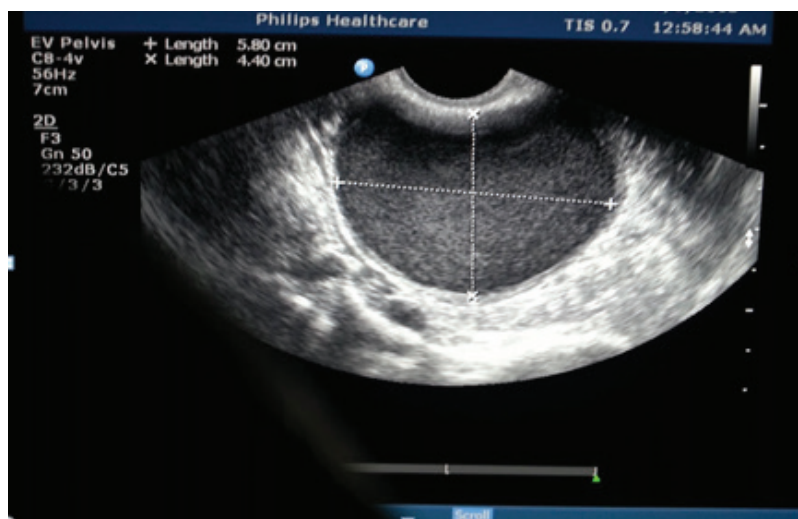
27 years female patient presenting with dysmenorrhea and irregular cycletransvaginal ultrasound show cystic lesion with homogenous low level internal echo.
